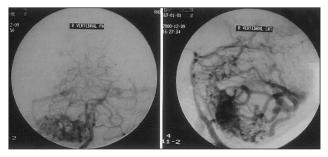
Pre-operative T2-weighted MR and angiography of right internal carotid artery and left vertebral artery of Case 2 showing Spetzler-Martin Grade 4 AVM.
